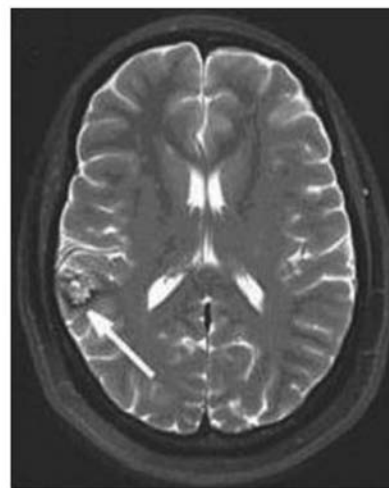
Radiological features of cerebral cavernous malformations (CCMs). T2 weighted MRI shows a right posterior temporoparietal cavernous malformation that exhibits the characteristic 'mulberry' appearance (arrow).
